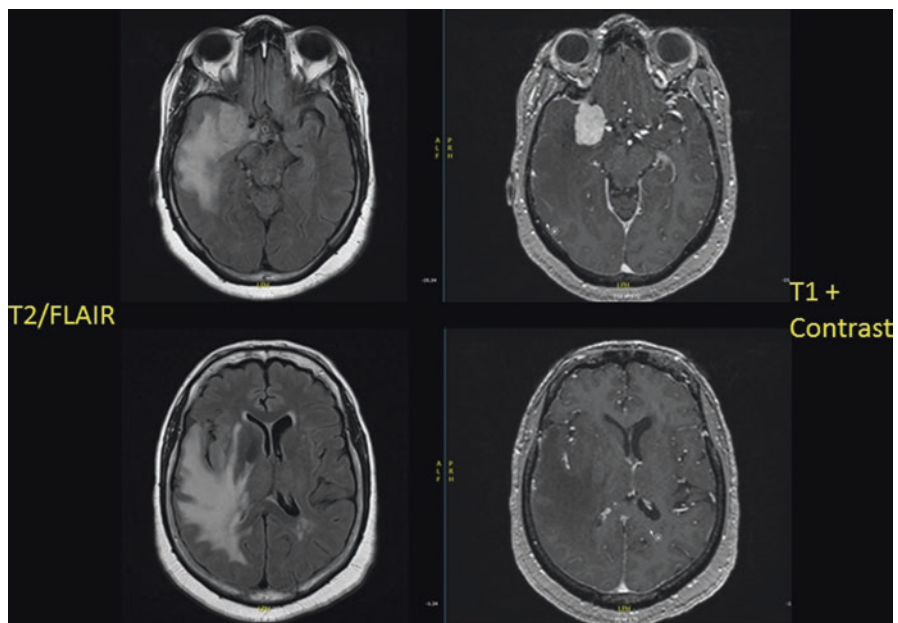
Brain MRI at the time of presentation for Ms. A (Case 1). Note the contrast-enhancing mass lesion arising from the dural surface and impinging on the right medial temporal lobe. Fluid-attenuated inversion recovery (FLAIR) sequences show extensive edema extending into the right temporal and frontal lobes as well as subcortical areas
